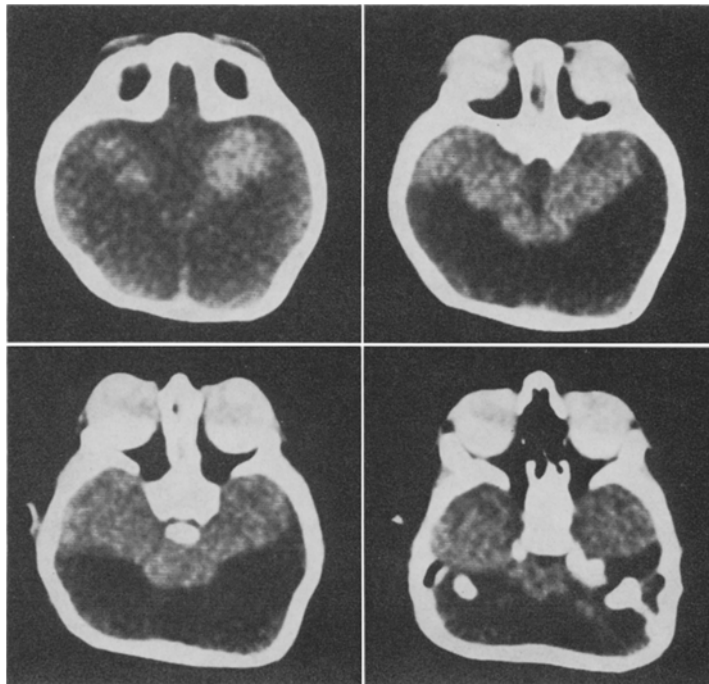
Brain CT scan of patient 1 at age 2 months, taken in 1982.
